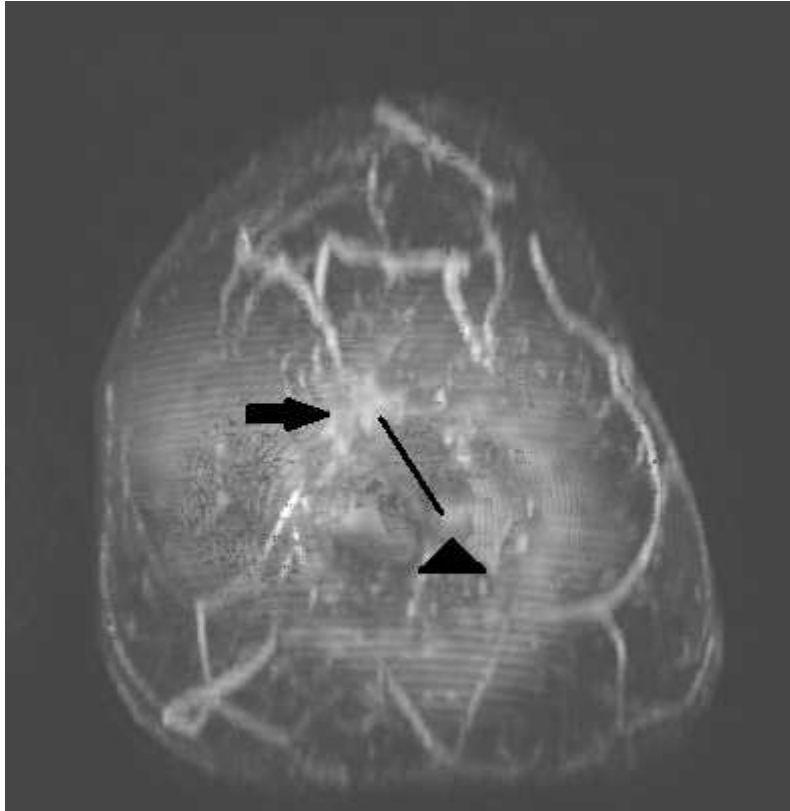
breast carcinoma on US and MRI
